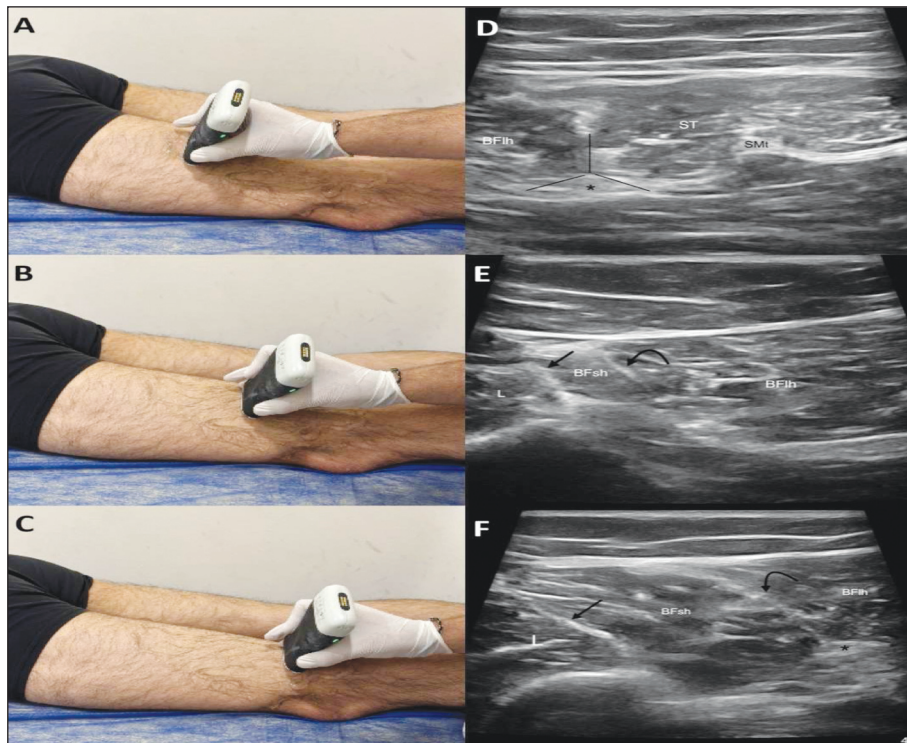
Sonographic evaluation of the hamstring complex. A, D) The common tendon of the Semitendinosus (ST) and the long head of the Biceps Femoris (BFh) in the axial plane in the proximal posterior region of the probe and the sciatic nerve at the center of the triad (*); B, E) When the probe is moved laterally and slightly distally, two parallel lines appear, the fascia between the short head of the biceps femoris (BFsh) and the lateral compartment (arrow) and the T junction between the short head of the biceps femoris and the long head of the biceps femoris (BFh) (curved arrow); C, F) When the probe is moved more distally, two parallel lines become clear, T junction between the long and short head of the biceps femoris (curved arrow) and the sciatic nerve (*).
